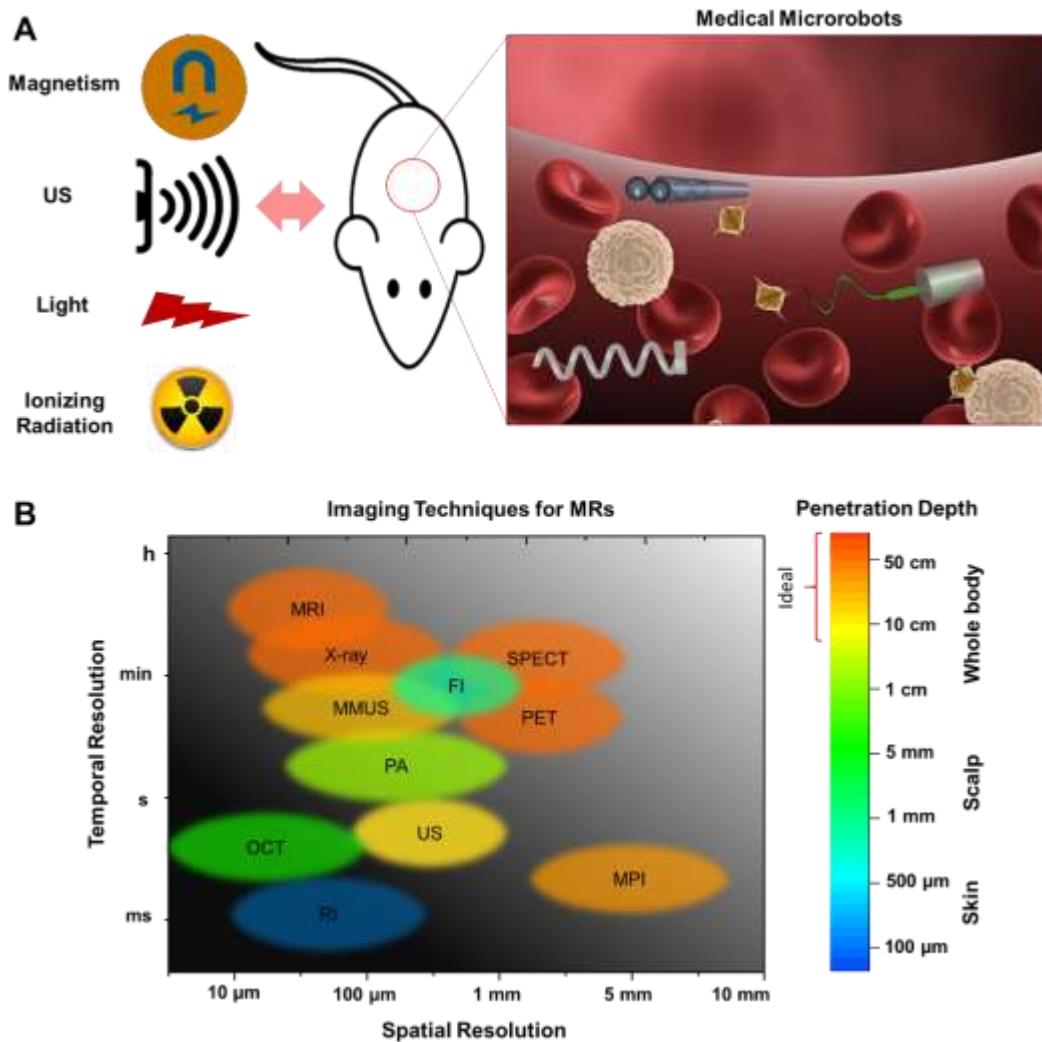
A) Imaging techniques to visualize and control medical MRs in living organisms. B) Spatial resolution, temporal resolution and tissue penetration depth overview of the most widespread biomedical imaging techniques: Magnetic Resonance Imaging (MRI); Magnetic
